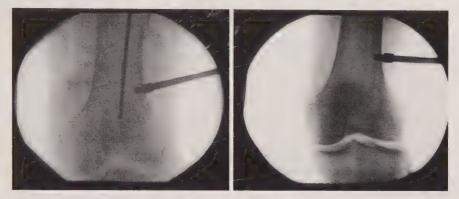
Anteroposterior roentgenograms of pressure sensor position at the supracondylar region
